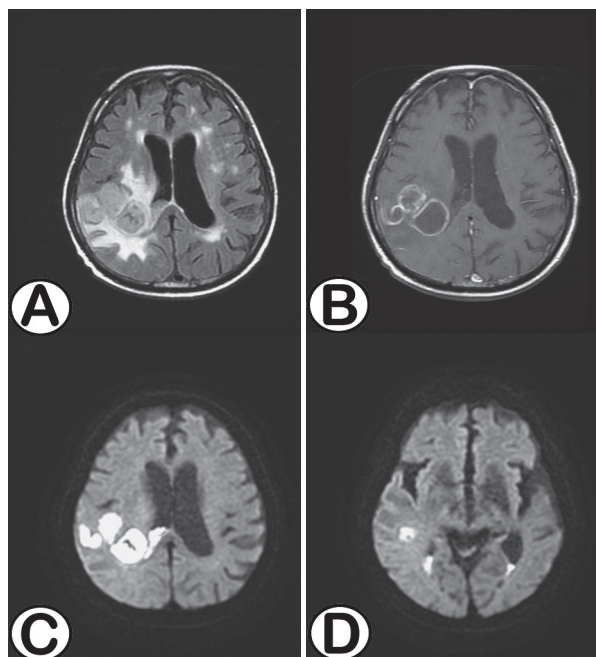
Brain magnetic resonance imaging performed on Day 149, during the last admission. (A) T2-weighted-fluid-attenuated inversion recovery (T2-FLAIR), (B) T1-weighted image (T1WI) with gadolinium enhancement. (A) and (B) revealed a multi-lobulated cystic lesion with marginal enhancement, accompanied by perifocal edema and compression of the right lateral ventricle, consistent with a pyogenic abscess. In addition, the FLAIR image displayed a rupture into the right lateral ventricle, which was further confirmed by diffusion-weighted imaging. (C) DWI at the same level as (A) and (B), showing a high signal in the right lateral ventricle, indicating abscess rupture, (D) DWI at an inferior level showing high signals at the dependent portions of bilateral lateral ventricles. DWI: diffusion-weighted imaging.
